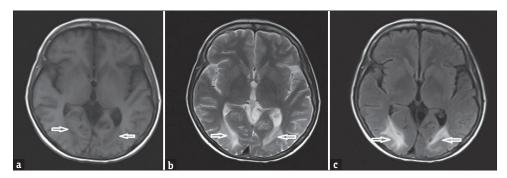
In both cerebellar hemispheres, in the bilateral occipital lobes, and in the supratentorial space, frontal and parietal white matter localization of hypointense T1 (a), T2 (b) and fluid attenuation inversion recovery (c) hyperintense multiple signal changes were observed through magnetic resonance imaging
